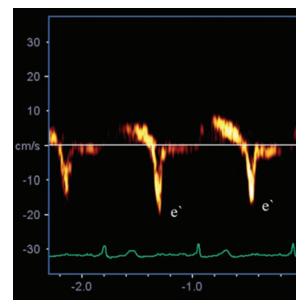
Mitral annulus tissue Doppler demonstrates an early diastolic velocity (e'), but no late diastolic velocity (a') is found. This image is from the lateral mitral annulus. There was no a'-wave noted in the superior, inferior, lateral or medial mitral annulus locations.
